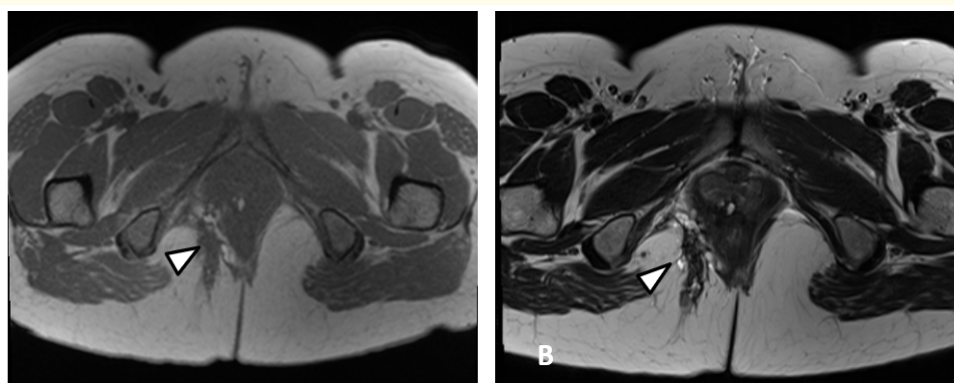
MRI Pelvis: Axial T1 Weighted Image (A) and Axial T2 Weighted Image (B): Show hyperintense nodules at the right lateral aspect of the posterior lower vaginal wall (arrow heads), denoting the lower vagina endometriosis.
